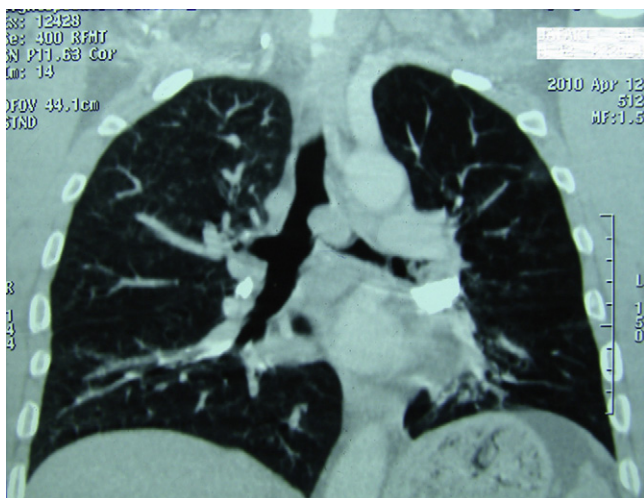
Preoperative CT scan (coronal section).
